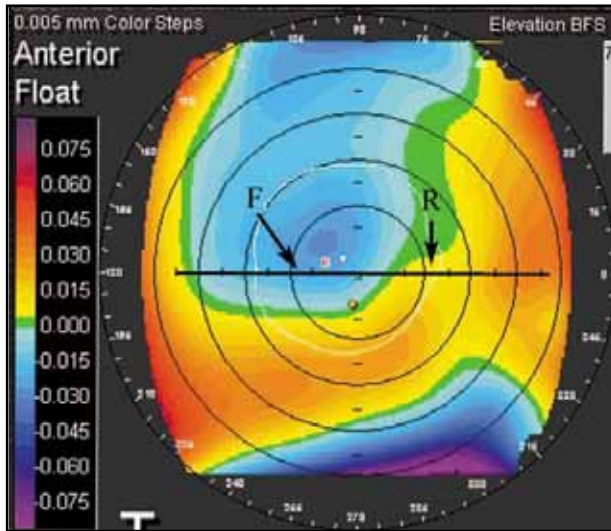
Orbiscan anterior best fit sphere (default 10-mm zone fit) plot of the cornea in a patient presenting with monocular diplopia and a topographic diagnosis of “decentered ablation” proved incorrect by B-scan imaging in the plane represented by the horizontal black line. Flatter (F) and raised (R) areas are correlated to the ultrasound B-scan in Figure 3-13.
